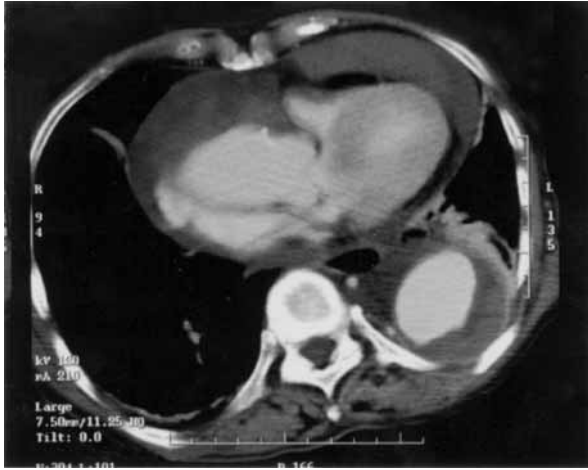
Contrast CT on admission. Extensive hemopericardium and dissecting cavity are found.
